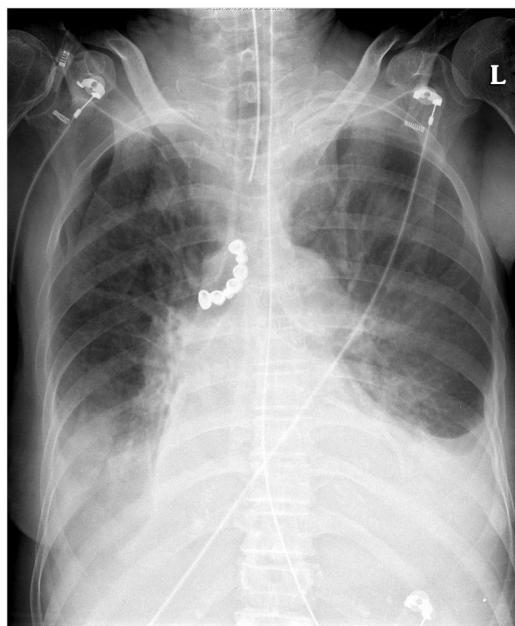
Anterior-posterior chest X-ray demonstrating the radiopaque 7-unit dental prosthesis (arrow) in the patient's right main bronchus.
